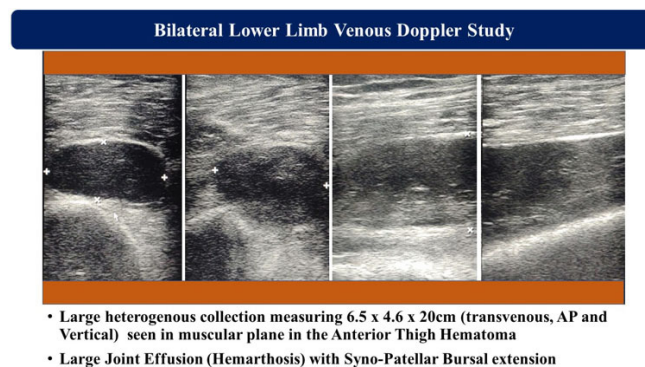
Bilateral Lower Limb Venous Doppler study.
